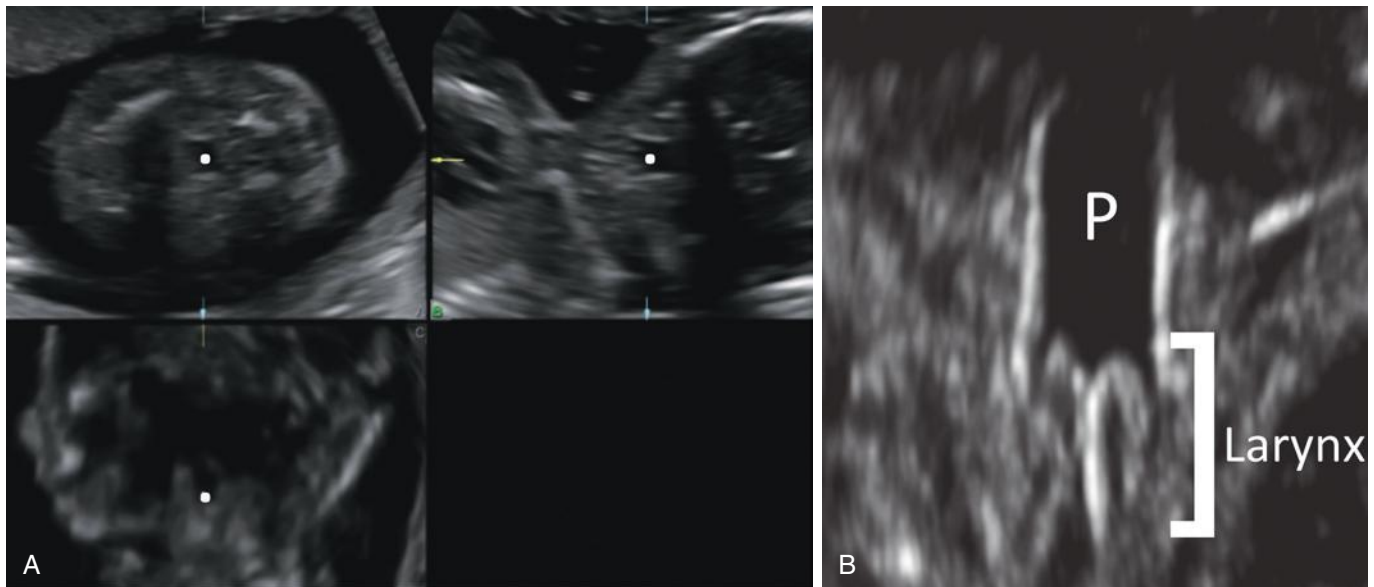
Normal ultrasound images of the fetal neck: A, Three-dimensional multiplanar display of the fetal neck acquired in the axial plane. The white cursor dot is centered in the pharynx in all three planes; upper left is axial, upper right is coronal, and lower left is sagittal. B, Coronal image of the fetal neck showing the pharynx (P) and larynx.
